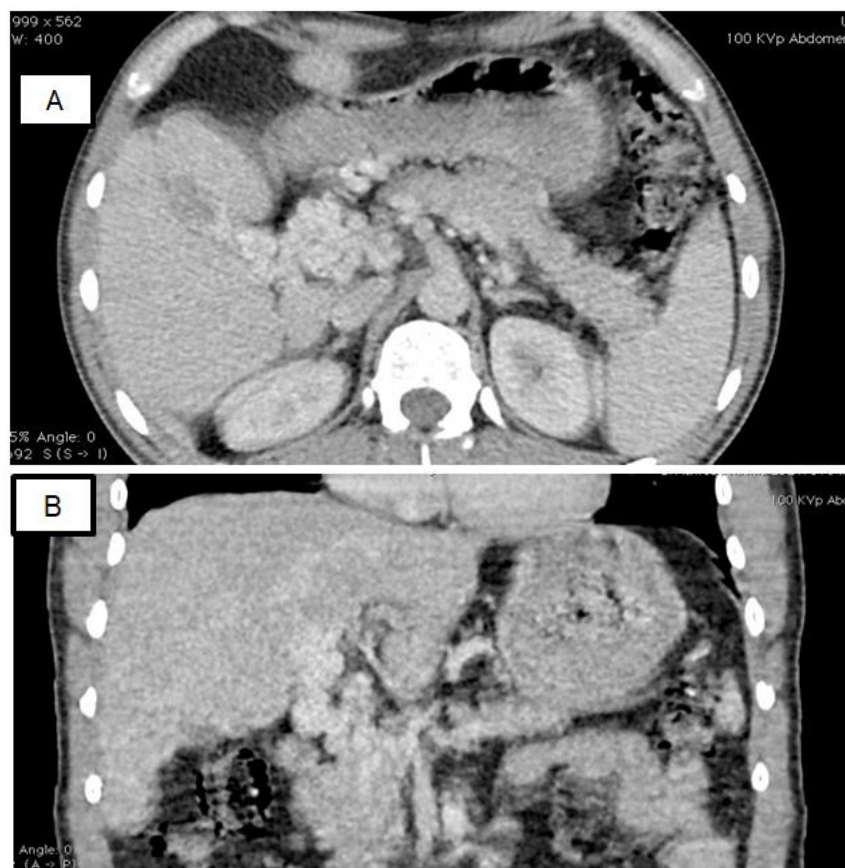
(A and B): Axial and coronal sections of an injected abdominal CT scan (in portal time) objectifying peripedicle varicose venous formations and hepatic hilum in a healthy liver
